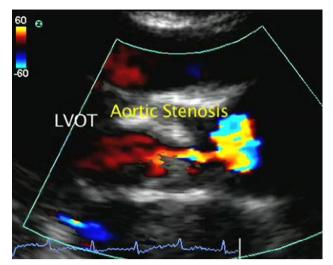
Critical aortic stenosis color Doppler LVOT view
